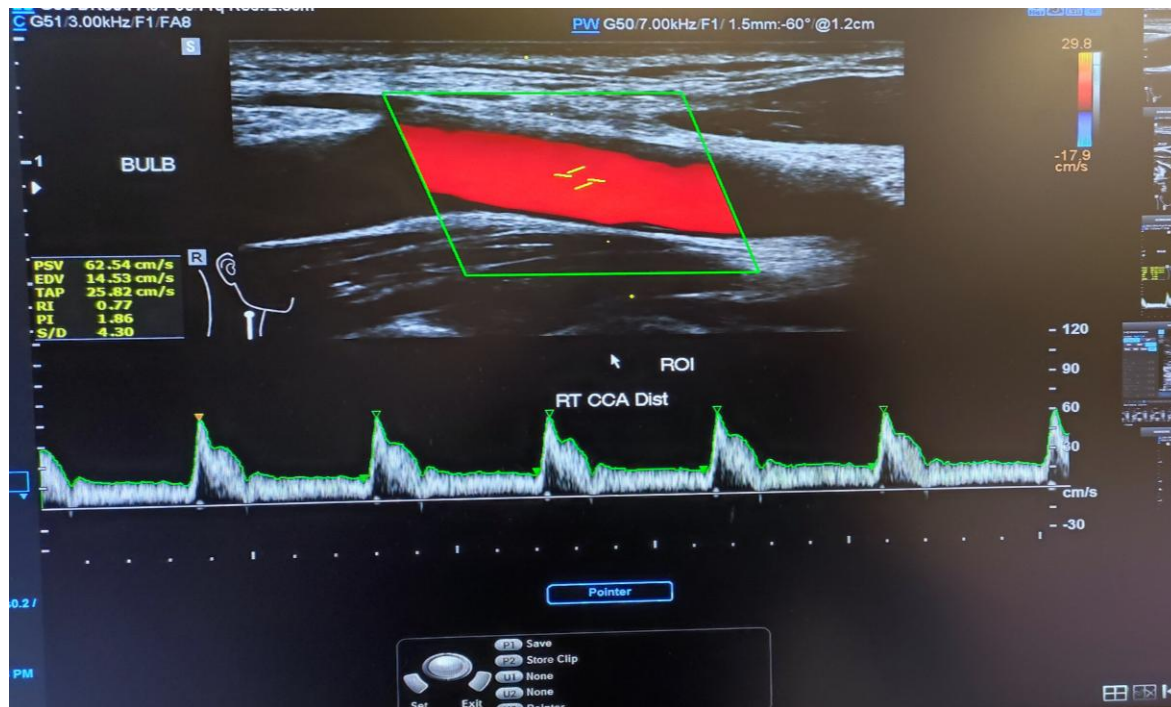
Image showing haemodynamic assessment of the Right distal CCA. Adapted from: own images Hong Kong Polytechnic University ultrasound lab, 2022.
